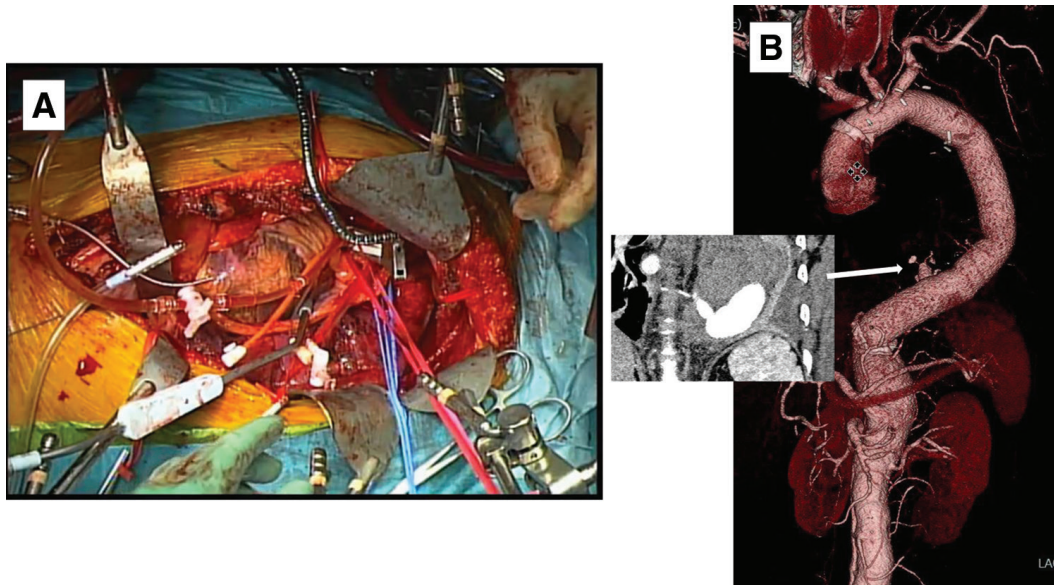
Single-stage aortic replacement from the ascending aorta to the diaphragm through the SIRC approach. (A) Operative view. The ascending aorta was cross-clamped and a cardioplegic solution was delivered through the aortic root. (B) Postoperative 3-dimensional computed tomography showing the patency of the reconstructed intercostal artery. SIRC: straight incision with rib cross
